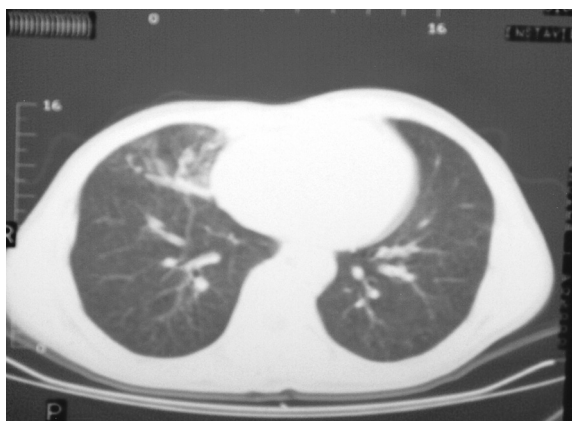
Chest CT demonstrated focal density adjacent to right heart border, indicating RML lesion.
